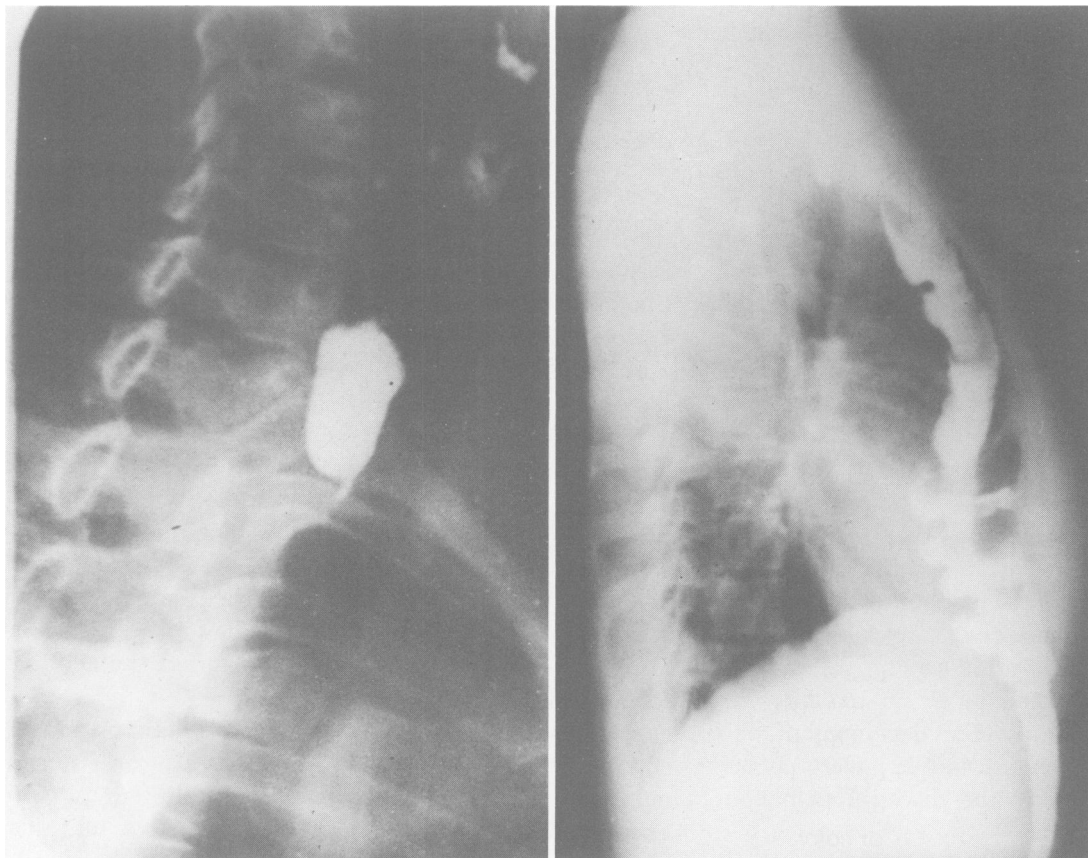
(left) Esophagogram of a 25-year-old woman with a history of lye injury. Note complete obstruction in the upper third of the esophagus. FIG. 1b. (right) Roentgenogram of the same patient 2 years after esophagoileocoloplasty showing well functioning retrosternal transplant.
